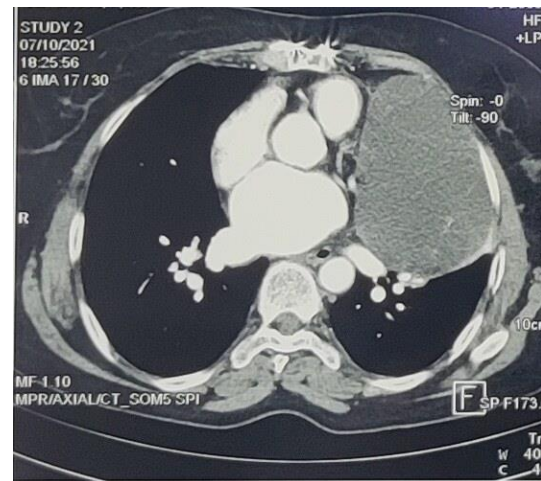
CT scan demonstrating large cystic lesion in anterior aspect of left lung.
